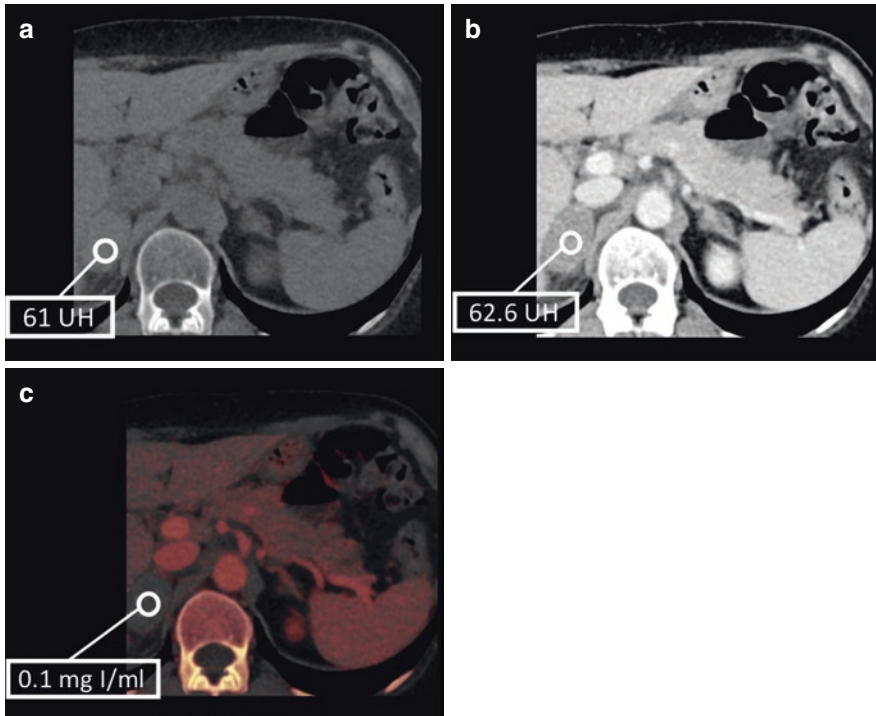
Virtual non-contrast (a), contrast-enhanced CT in the venous phase (b), and post-processed iodine map (c) show a spontaneously hyperattenuating right adrenal
